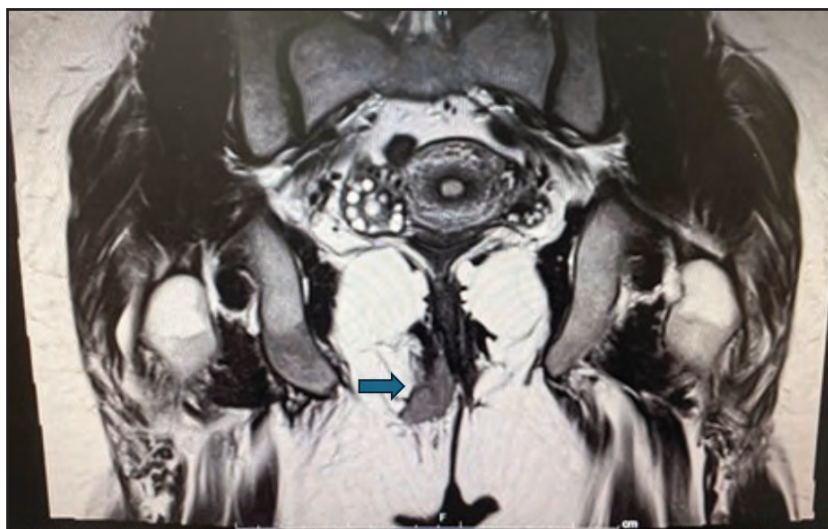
Coronal view of MRI of the pelvis demonstrated lobulated mass involving lower third of vagina extending to right vulva region
